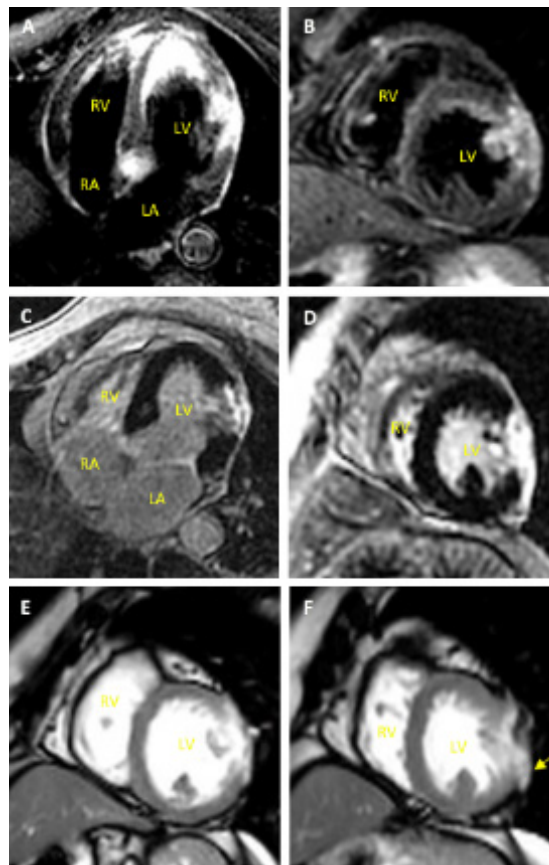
Cardiac magnetic resonance imaging. (A) Four-chamber and (B) short-axis views, T2-weighted short-tau inversion recovery (STIR) images, showing transmural hyperintense sign of the mid-segment of the lateral wall compatible with oedema; (C) Four-chamber and (D) short-axis views, late gadolinium enhancement images, showing contrast enhancement of the same segment, suggesting myocardial necrosis; (E) End-diastolic and (F) end-systolic phases, steady-state free precession (SSFP) cine images, showing dyskinesia of the mid-segment of lateral wall and a saccular protuberance suggesting a pseudoaneurysm (yellow arrow).
